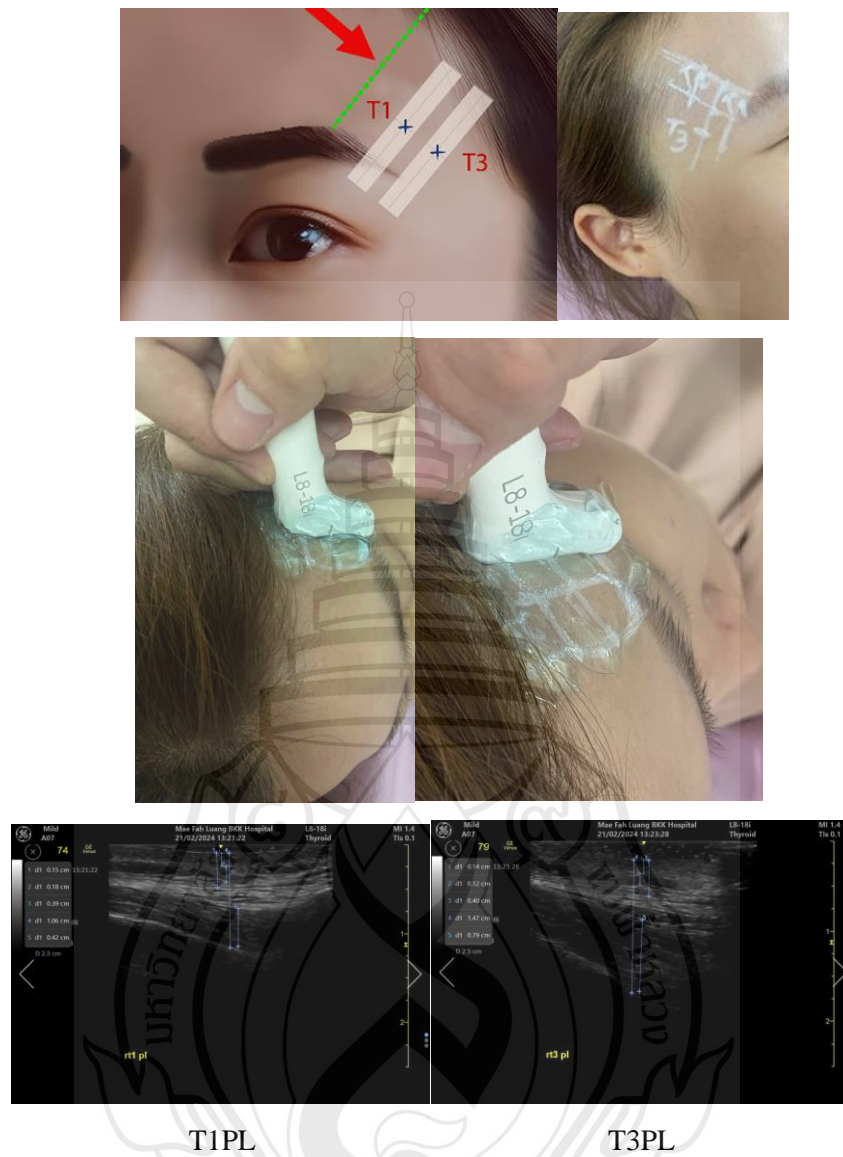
Photos of subject during temporal ultrasound detection parallel to the temporal crest at Points T1 and T3 (T1P& T3PL)
